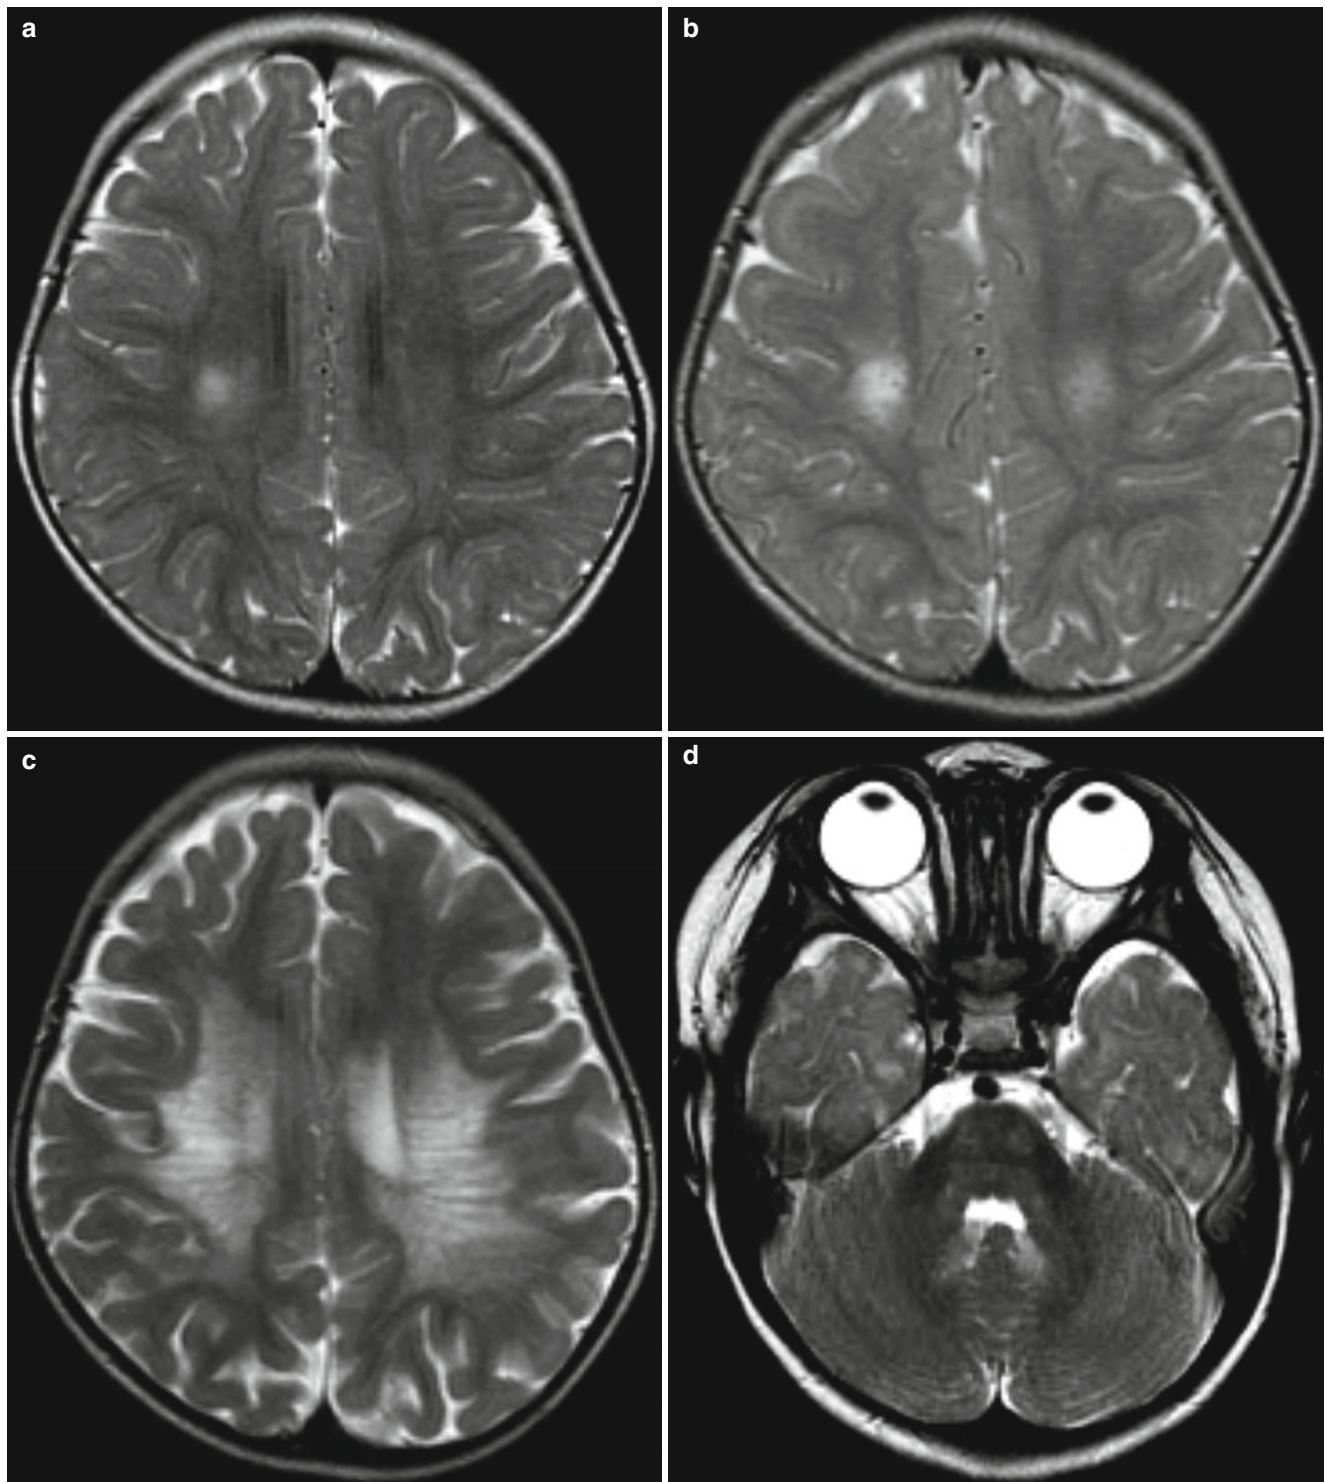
Krabbe disease in an infant with irritability and spasticity (a–d). (a) T2-weighted image shows focal high signals in the right centrum semiovale. (b) Four-month follow-up image shows slight progression of the lesion and newly developed left white matter lesion. (c) Further follow-up after 1 year shows progression of the confluent
